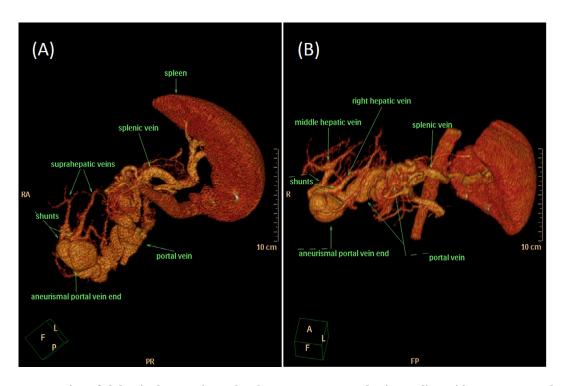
3D reconstruction of abdominal CT angiography shows tortuous portal veins ending with an aneurysmal shunt into the suprahepatic veins
